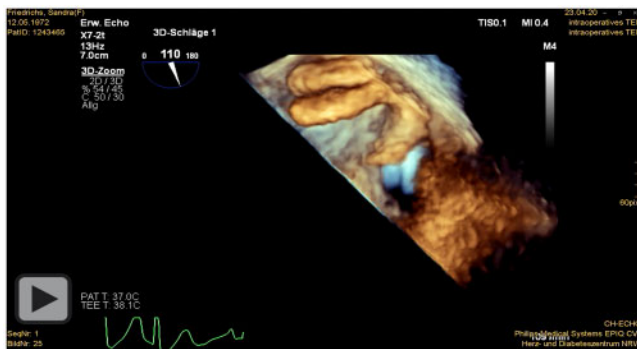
This figure shows the extend of the thrombus in (A) transoesophageal echocardiography, (B) computed tomography scan with adjacent beam hardening artefacts due to the atrial probe, and (C) in the right atrium intraoperatively. LA: left atrium; RA: right atrium, arrow point to the thrombus; 1: inferior caval vein cannula; 2: fossa ovalis and patent foramen ovale.
